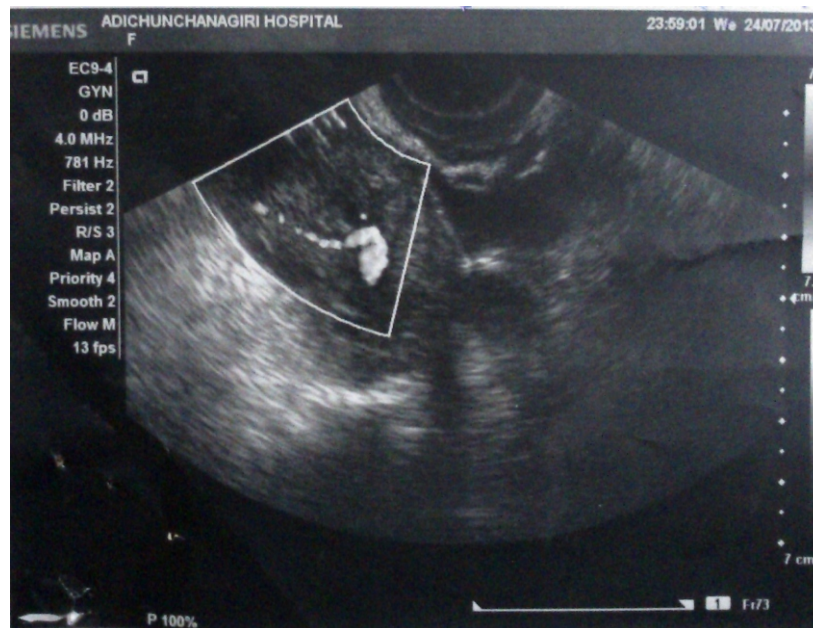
Ultrasound showing left adnexal mass with increased vascularity
